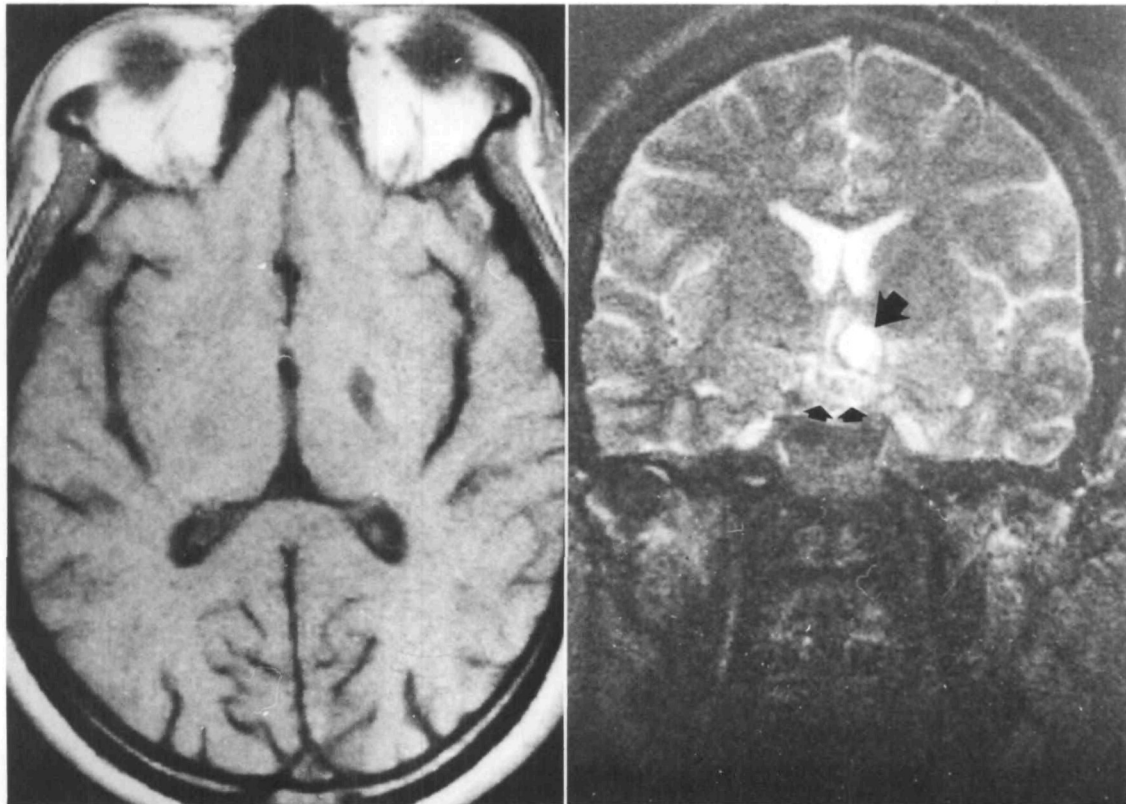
Left: T1-weighted (echo time 520 msec, repetition time 21 msec) magnetic resonance image showing left capsular infarction. Right: T2-weighted (echo time 2000 msec, repetition time 50 msec) magnetic resonance image showing suprasellar cysticercus (large arrow) with surrounding arachnoiditis (small arrows).
